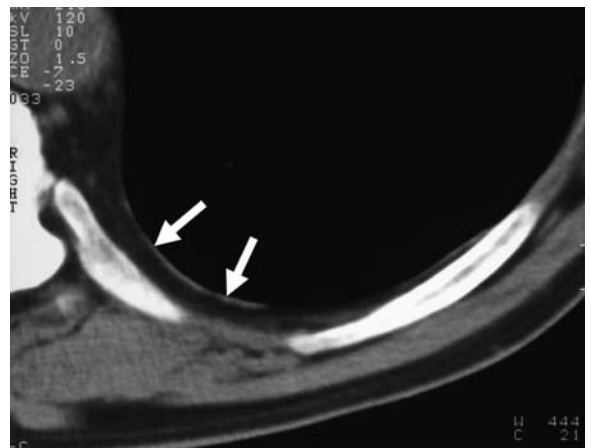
Computed tomography scan of the chest shows posterior pleural plaque appearing as a discrete smooth line of soft tissue attenuation (arrows)
